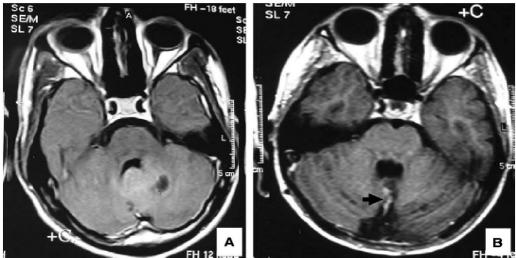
(A, B). In (A) axial T1-weighted MRI with Gd-DTPA showing vermian tumour with inhomogenous contrast enhancement. In (B) postoperative axial, T1-weighted MRI with Gd-DTPA showing total tumour removal. Injured vermis is indicated by black arrowhead. It was a medulloblastoma and the pre-existing ataxia was permanently worsened.
